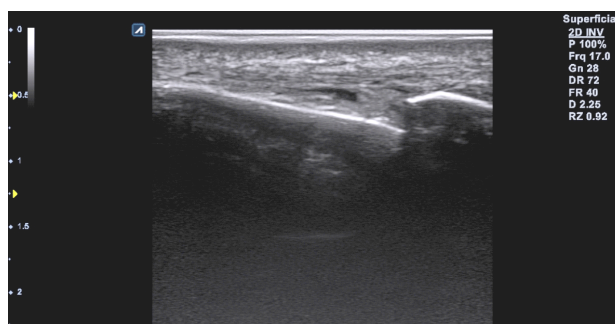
Ultrasound image, with 18 MHz of PIP joint arthroplasty, longitudinal section, flexor and extensor tendons dislocated. PIP: Proximal interphalangeal.
